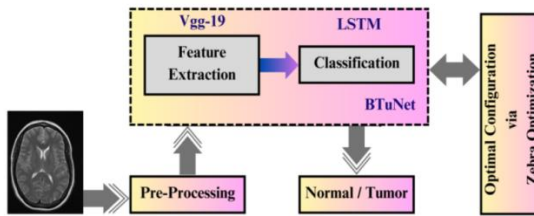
Overall Research Flow for MRI Brain Image Classification
